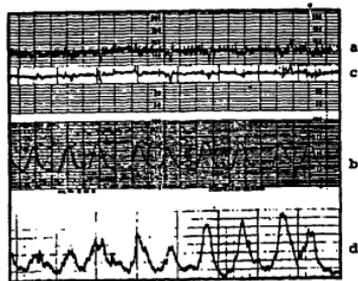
Cardiotocogram based on ultrasonics (a) and tocotransducer (b) compared to abdominal lead registered CTG (c) and (d).
